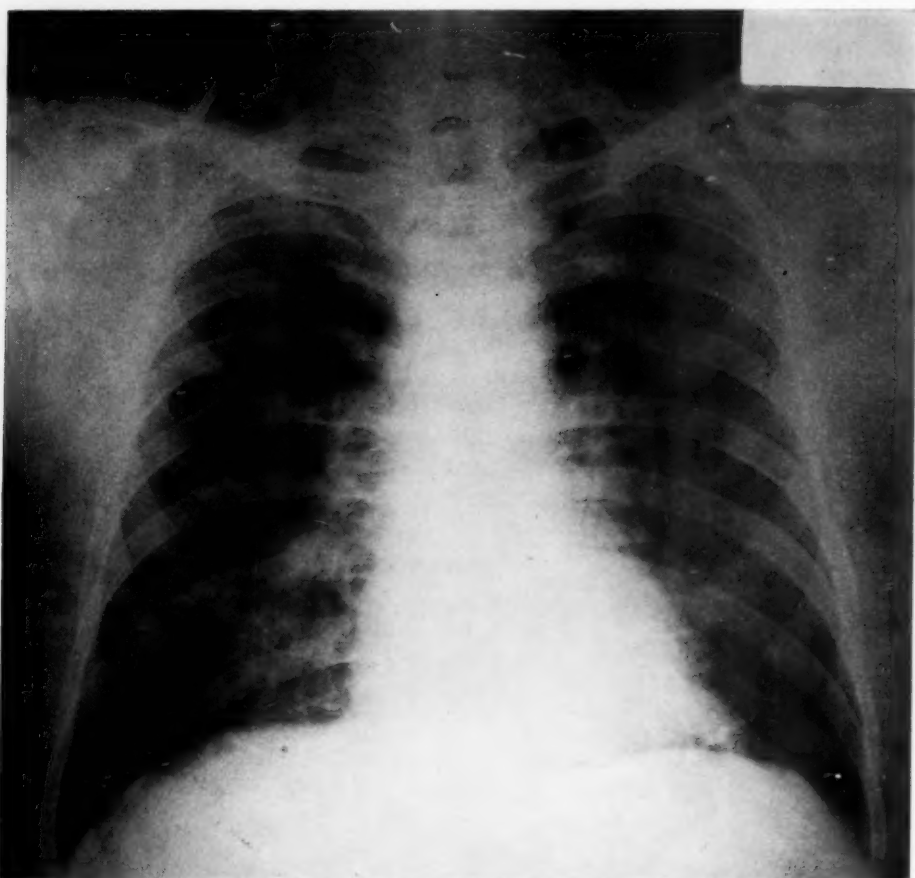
(Case 5.) Roentgenogram taken September 29, 1939. Both lung fields clear.
